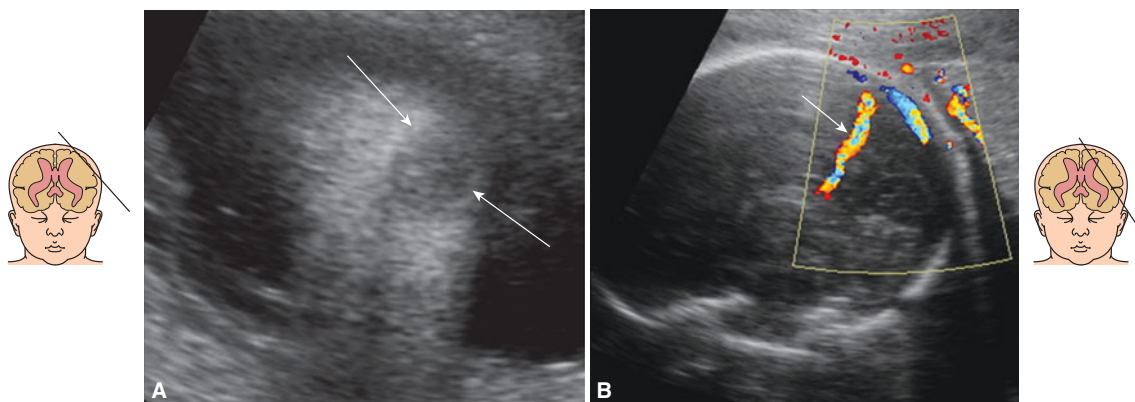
Transabdominal sonography at 29 weeks, 6 days. (A) Parietal bone round defect (arrows), (B) Color Doppler of the abnormally large vein (arrow) reaching the parietal bone at the level of the defect. (Courtesy of Gustavo Malinge.)
